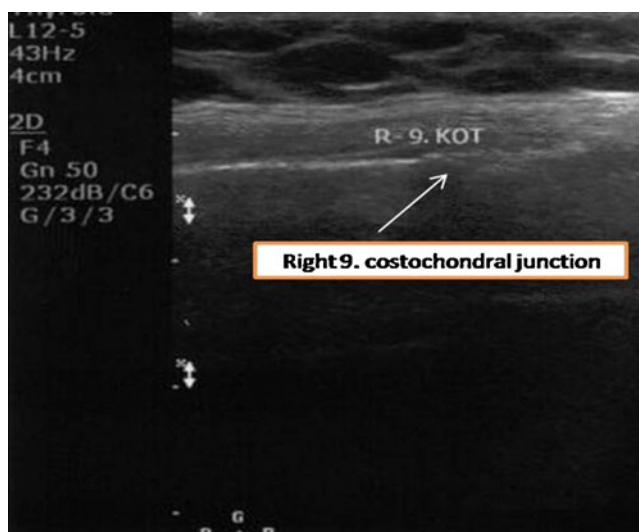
The ultrasonographic image of a costochondral junction fracture
